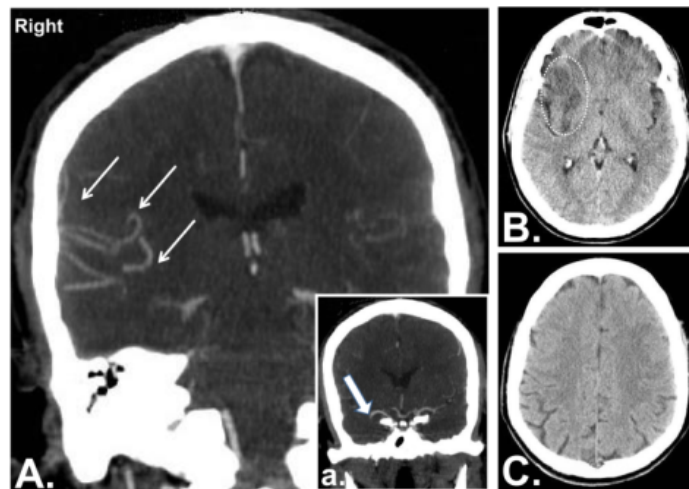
Imaging of cerebral collaterals with CT-angiography in a patient with acute ischemic stroke. Collateral vessels (A. small arrows) are visible in the right hemisphere. These vessels have been recruited after acute right MCA occlusion (a. large arrow). This patient was treated with intravenous thrombolysis and developed a small subcortical lesion (B), while the entire cortical territory was intact (C), due to the residual blood flow provided by the collateral circulation in the hyperacute phase, before recanalization was achieved. CT = computerized tomography; MCA = middle cerebral artery. Reproduced from Coyle and Jokelainen, 1982 (Coyle and Jokelainen, 1982)
